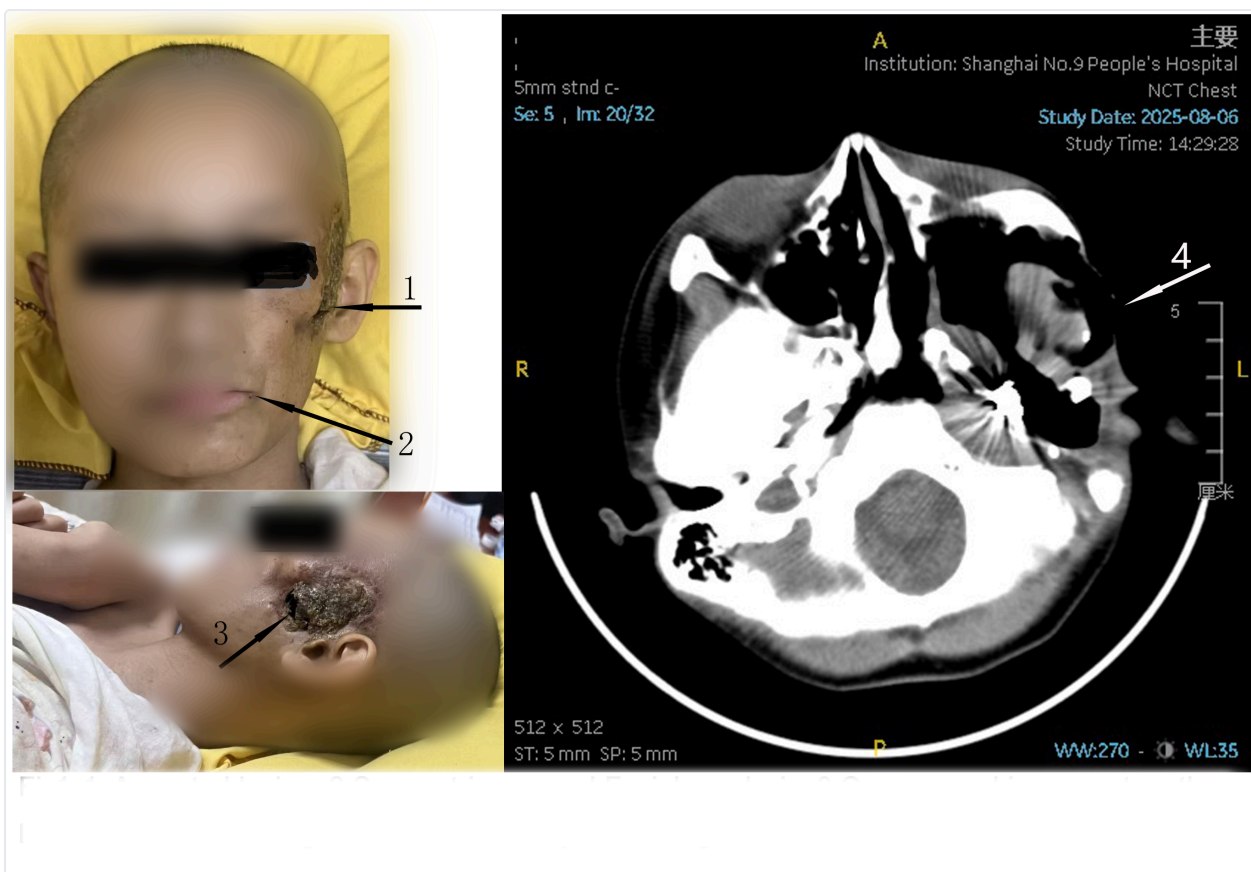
1 A crusted lesion; 2 Severe trismus and Facial paralysis; 3 Open wound is present on the left face, communicating with the oral cavity; 4 CT image shows oronasoalveolar fistula.
